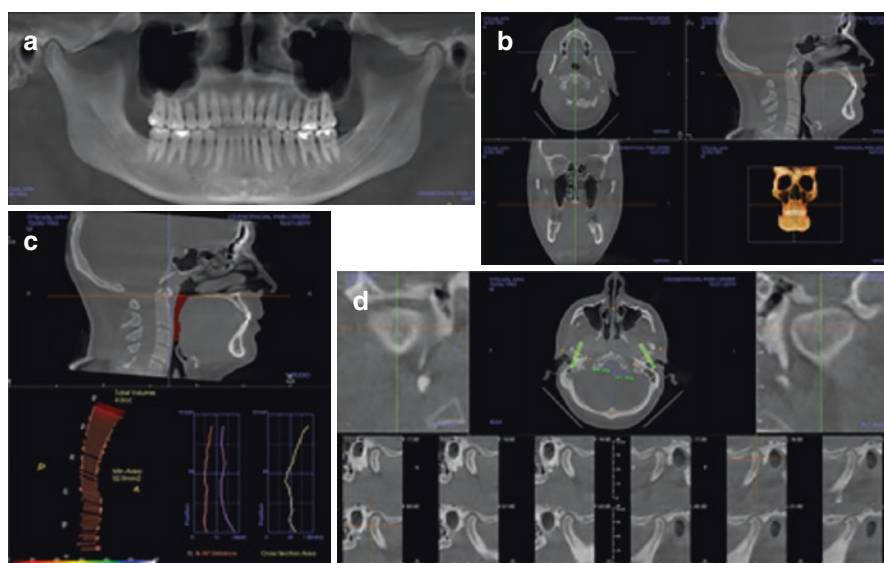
CBCT evaluation: (a) The upper left figure is a panoramic radiograph of patient D.M. (b) The upper right figure is an overview, but the lateral cephalometric shows narrowed oropharyngeal airway at the base of the tongue. The lower left showing hypertrophy of inferior nasal turbinates. (c) The lower left figure shows the lateral view; oropharyngeal airway is shown in red. (d) Lateral view of the TMJ, showing bilateral posterior/superior displacement of the mandibular condyles
